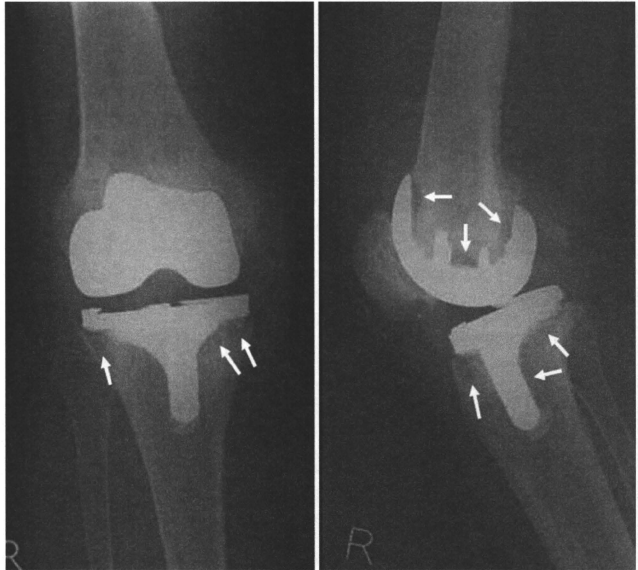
Radiographs of the right knee 11 months after the primary total knee arthroplasty (TKA). Osteolysis around the femoral and tibial components is evident (arrows)
